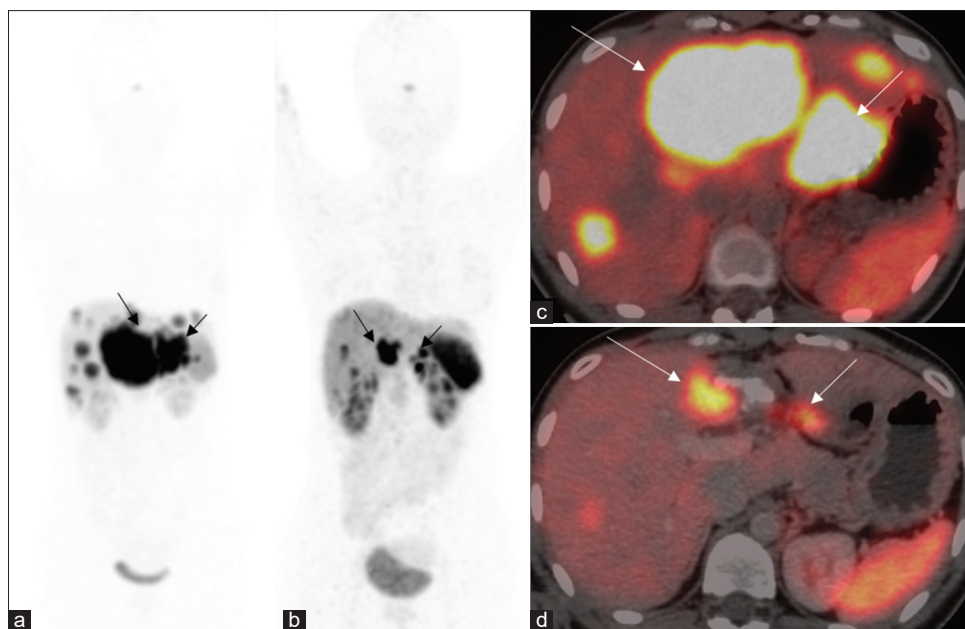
A 28-year-old female, case of WHO Grade 2 NET of liver with extensive disease involvement on baseline Ga-68 DOTATATE PET/CT, which shows bilateral lobar involvement, with dominant lesion in segments II (a and c: block arrow) and IVA (a and c: arrow) of liver and multiple focal liver lesions in rest of hepatic parenchyma. Two cycles of IA PRRT was administered. After 8 weeks following the 2nd cycle, Ga-68 DOTATATE PET/CT was performed. Compared to baseline, there is significant response seen in segment II (b and d-block arrow) and IV A (b and d: arrow) lesions. Also, there was complete metabolic regression in the majority of the focal liver lesions. Patient is now being considered for hepatic transplantation. PET/CT: Positron emission tomography/computed tomography, IA PRRT: Intra-arterial peptide receptor radionuclide therapy, NET: Neuroendocrine tumor
